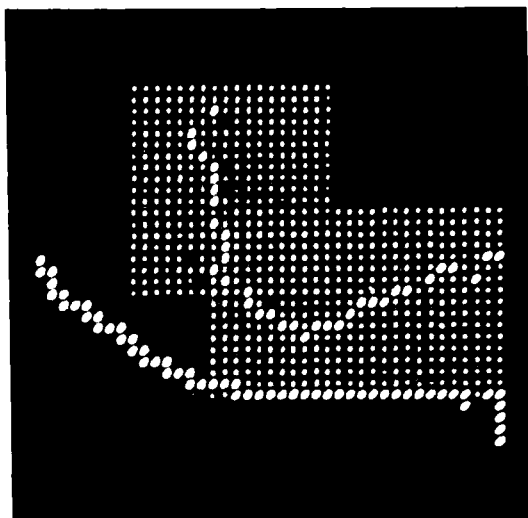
Outline of the anterior part of the mandible determined for the x-ray image in Fig. 1.
